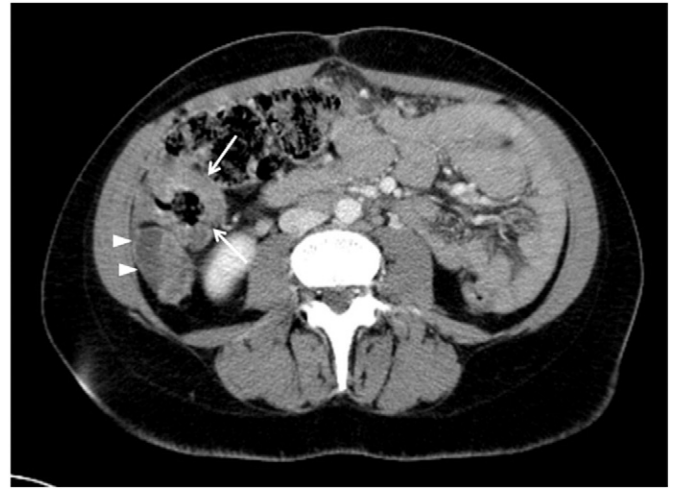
Transverse multidetector row CT image obtained at lower level shows thickening of caecum wall (arrows). Dilatation of appendiceal lumen by mucin accumulation was also evident (arrowheads).
